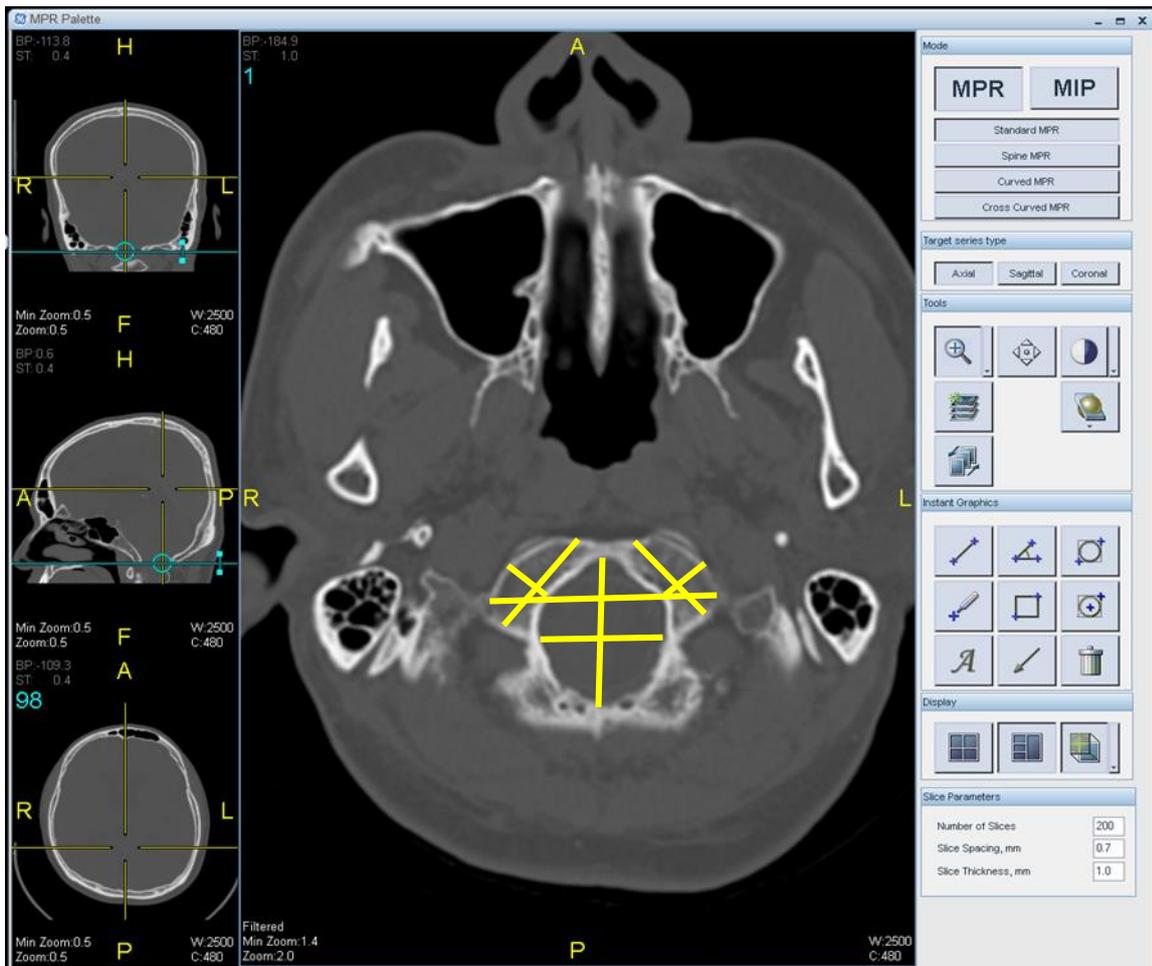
Measurement of FM morphology in MPR CT brain image
